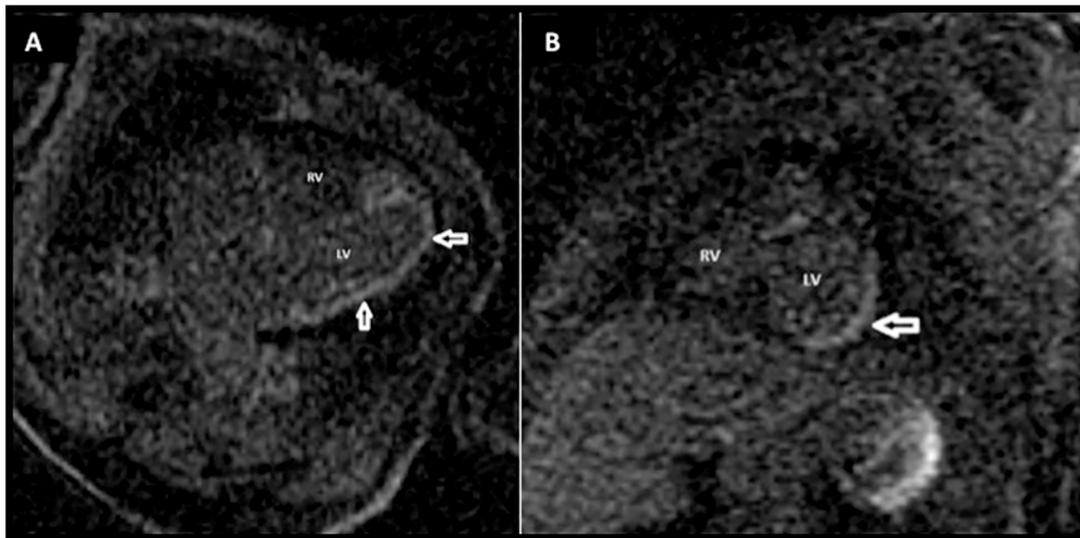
Cardiac MRI with delayed enhancement utilizing an SSFP coronary artery sequence following the administration of 0.5 ml of gadolinium-based contrast demonstrating an area of sub-endocardial enhancement (white arrow) along the inferolateral and inferior segments of LV basal region, anterior, anterolateral, inferolateral, inferior and inferoseptal segments of LV mid-cavity. The myocardial enhancement appears to be mostly in the left circumflex territory with some segments of LAD and RCA territories. (A) 4-chamber view. (B) Short-axis view.
